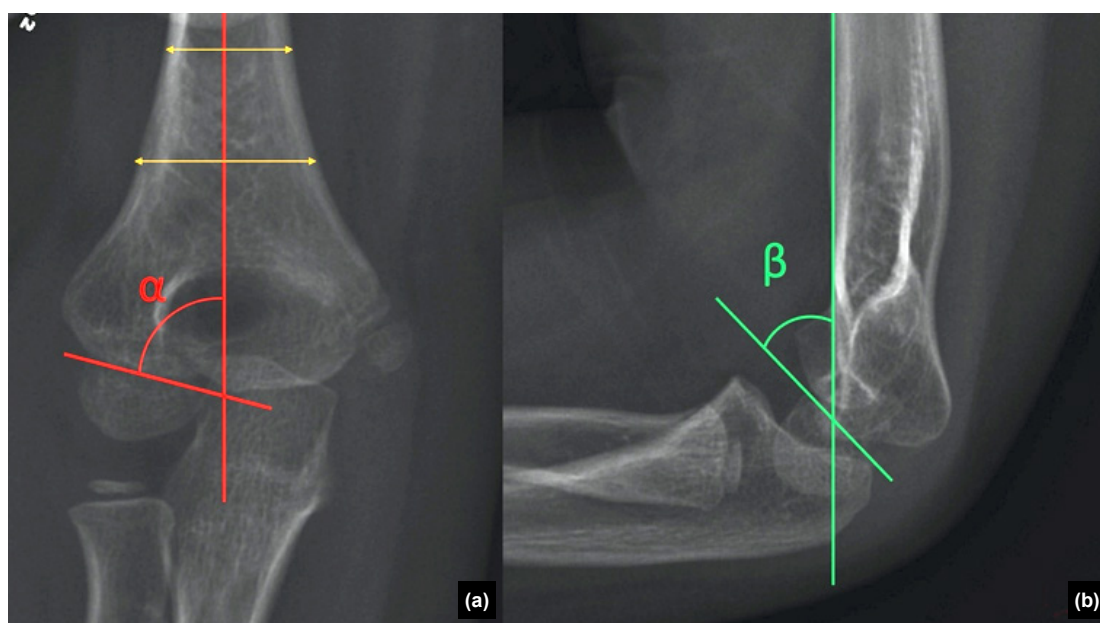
X-ray images show the 3-year follow-up of an 8-year-old male patient with a right elbow Type I fracture. (a) demonstrates the Baumann angle on an anteroposterior X-ray. The Baumann angle (α) is defined as the angle between the longitudinal axis of the humeral shaft and a line tangential to the lateral condylar physis (the red line). (b) shows the lateral elbow X-ray of the same patient. It demonstrates the Lateral Capitellum Humeral Angle (LCHA), (β) which is defined as the angle between the anterior axis of the humeral shaft and the proximal margin of the capitellum (the green line).
